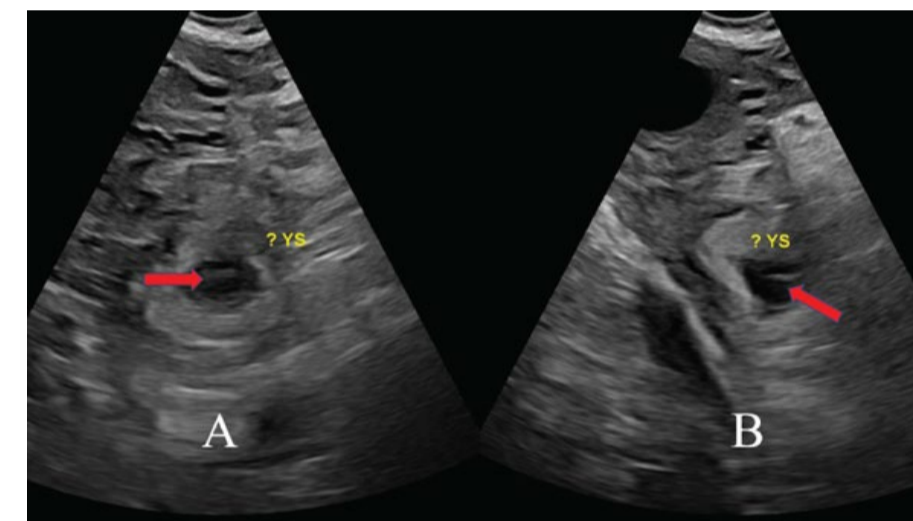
Longitudinal (a) and transverse (b) transvaginal ultrasound images of the right adnexa structure demonstrate possible internal echogenicity or septations (red arrow) which may represent a yolk sac or reverberation artifact.
